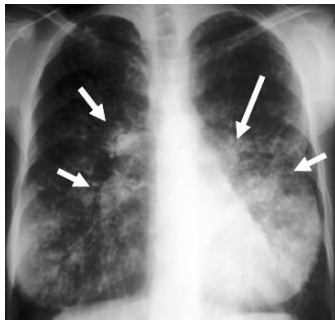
An X-ray photograph of a patient with cystic fibrosis. The mucus is not visible on a photo of a healthy person, however, the tough mucus of a CF-patient is visible as white spots in the picture (see arrows).
